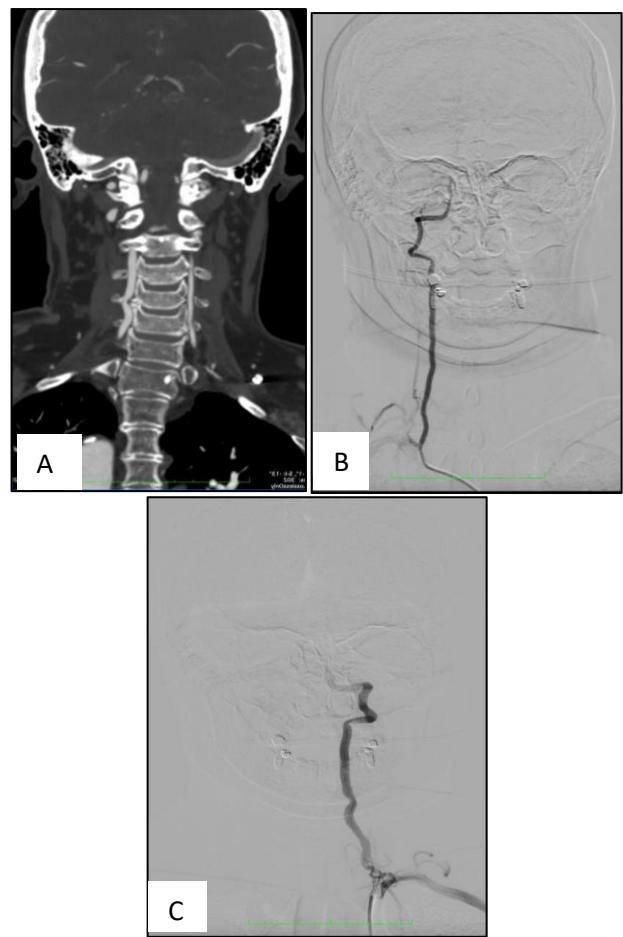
Ancillary examination of (A) head-to-neck angiography CT scan revealed cervical spondylosis with osteophytes left of C5-C6 vertebra, (B) digital subtraction angiography of right vertebral artery demonstrated hypoplasia, supported with the insufficient contrast filling at the basilar artery, (C) digital subtraction angiography of left vertebral artery showed normal finding.
